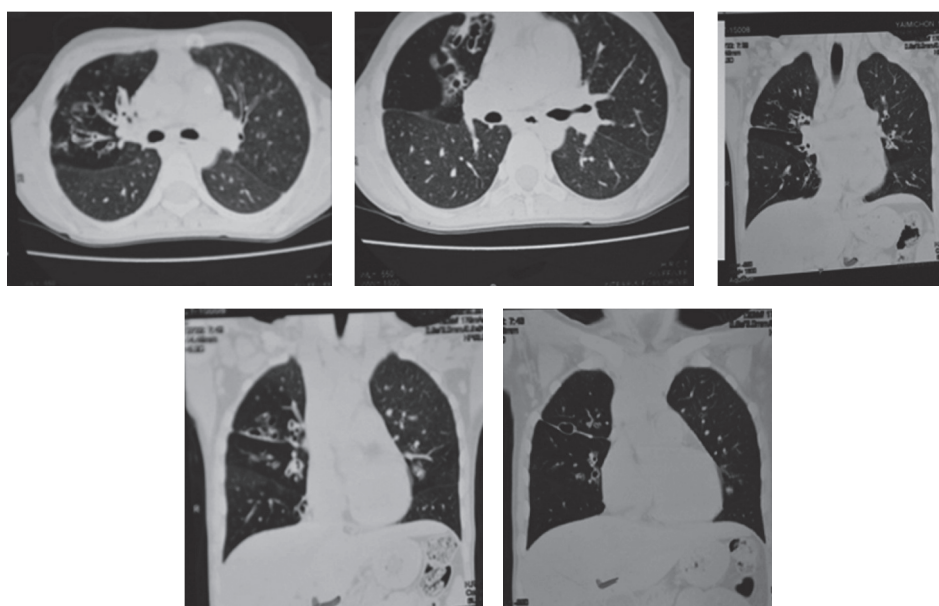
A 12- year- old female patient. A. HRCT images shows air trapping mosaic & ground glass opacities attenuation associated with cystic and cylindrical bronchiectasis predominantly in the upper lobes of right lung. Sub pleural interstitial thickening pulmonary fibrosis also noted in the right apical-posterior segment. Left lingual sub segmental cystic bronchiectasis is seen with air trapping mosaic attenuation.
